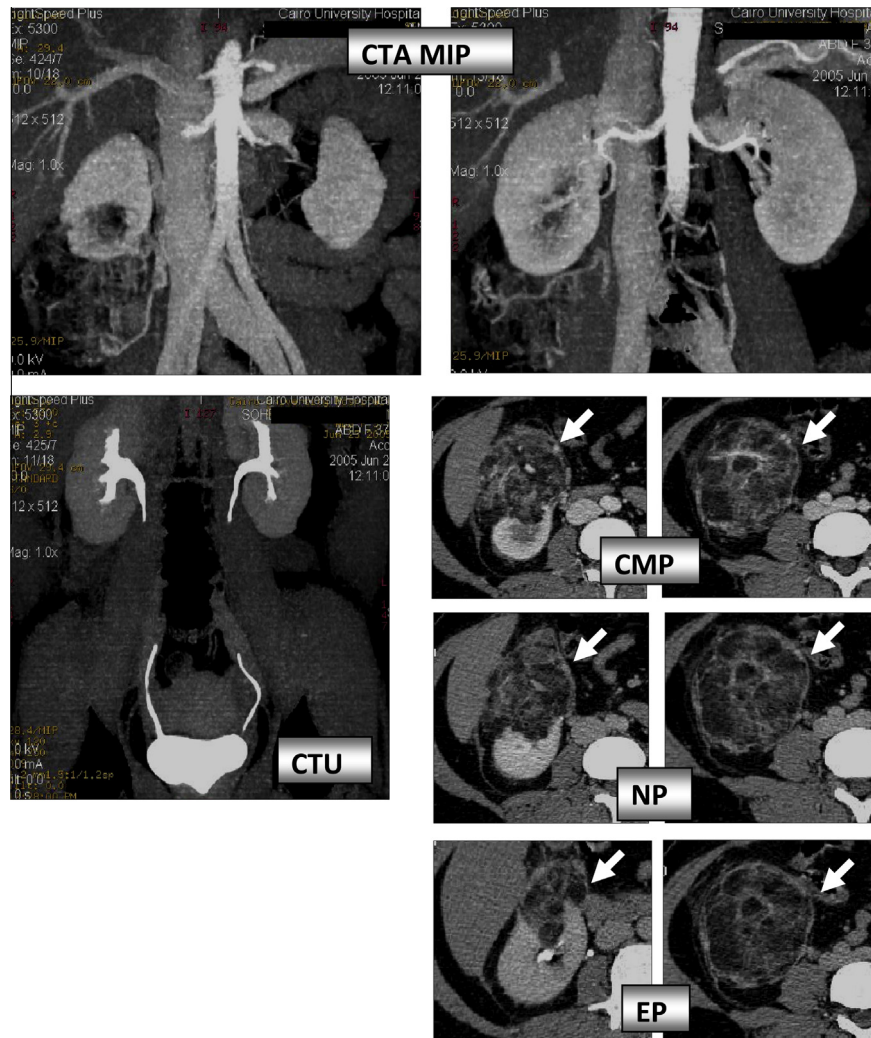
MDCT: Large right renal lower pole cortical soft tissue mass showing heterogeneous texture, areas of intense enhancement and areas of fat densities (arrows). CTA: No pathological circulation. Multiple dilated and tortuous vascular channels with early venous filling of the hypertrophied draining veins. CTU: No abnormality detected. Diagnosis: Angiomyolipoma.
